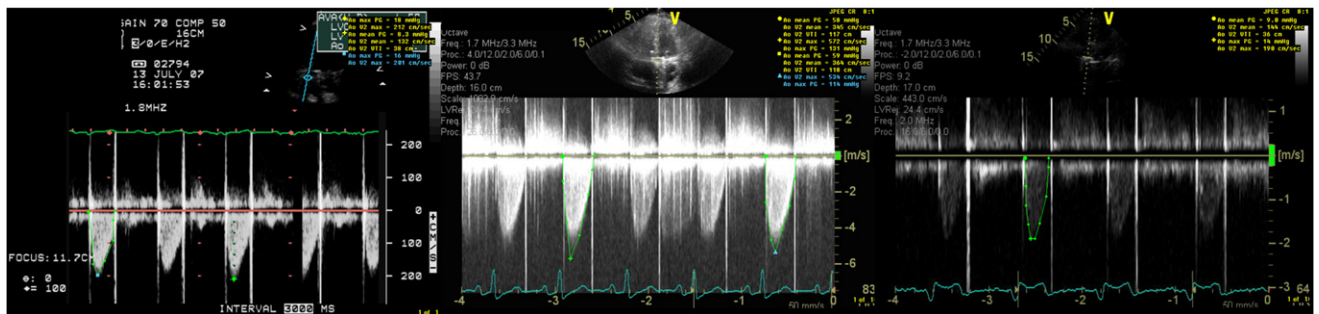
Mean gradient across the mechanical aortic valve measured using continuous-wave Doppler before (10 mm Hg) (left) and after (59 mm Hg) (middle) thrombus development and after thrombectomy (9 mm Hg) (right).
